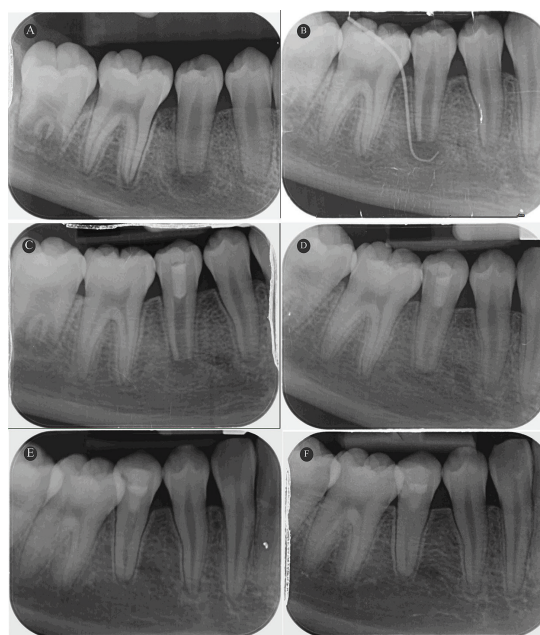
Periapical radiographs of the mandibular right second premolar during the regenerative endodontic treatment: (A) a pre-operative periapical radiograph showed an immature root with a periapical lesion; (B) a sinus tracing radiograph; (C) a radiograph post-induced bleeding into the root canal and coronal restoration showed a reduction in the size of the periapical lesion; (D) a 6-month follow-up radiograph showed continued root development and a widening of the periodontal ligament space; (E) a 10-month follow-up radiograph showed continued root development with radiopacity in the root canal and a widening of the periodontal ligament space; and (F) a 22-month follow-up radiograph showed continued root development with a closed apex and normal periapical tissue.
